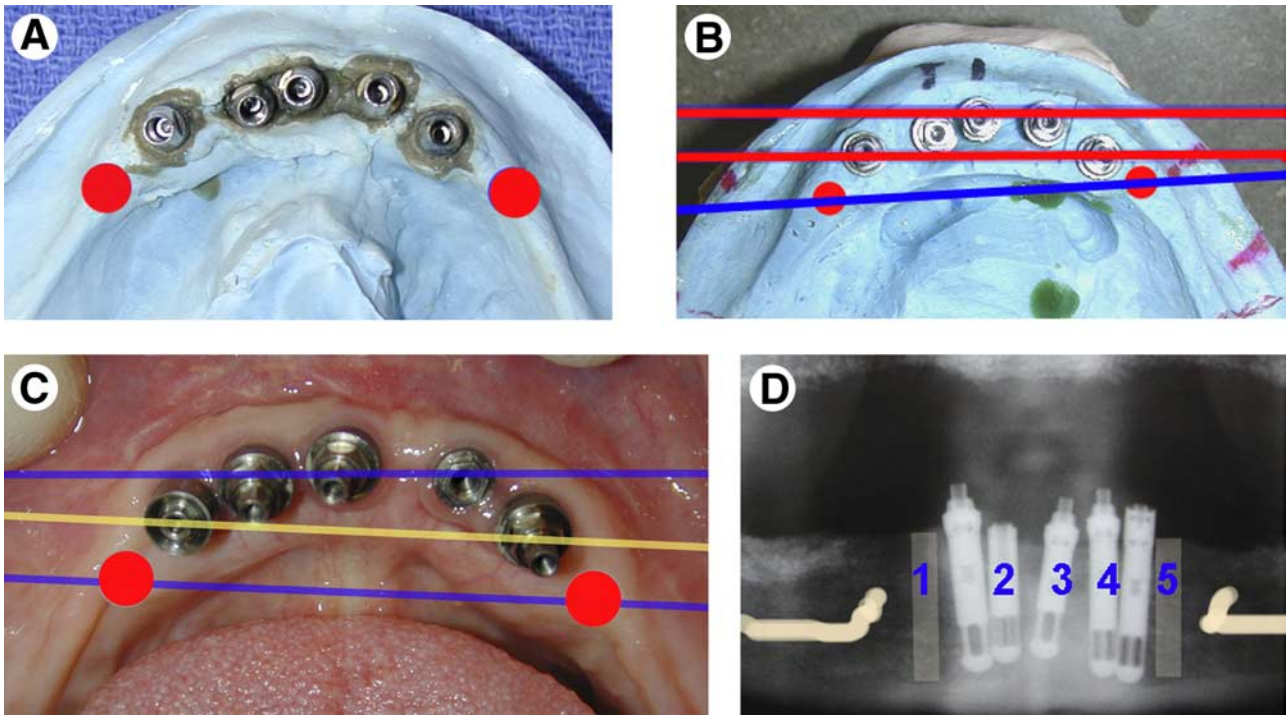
A, Implants placed in nearly straight line. Radiographs indicated that the implants could have been placed further distally. B, The anterior-posterior (A/P) spread would have been double had the implants been located in the more distal site. Implants could have spaced more ideally and crowding could have been avoided. C, Another case where the A/P spread could have been significantly improved. D, Radiograph indicates what the proper spacing of the implants should have been.
